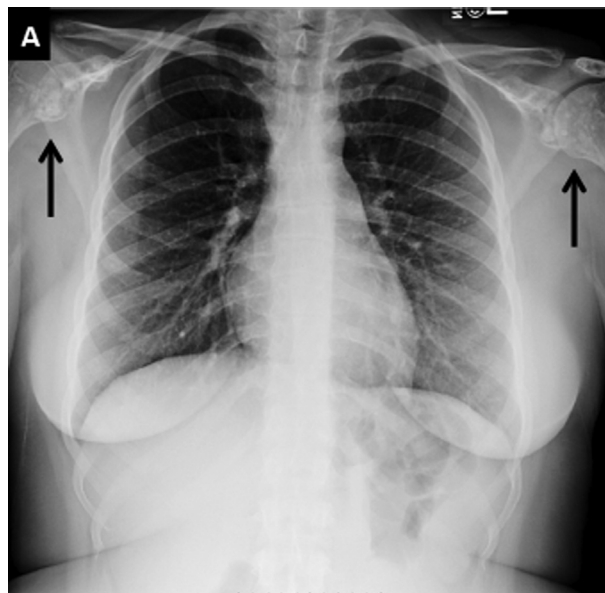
Osteopoikilosis: frontal chest radiograph (A). Note the innumerable punctate sclerotic lesions in the proximal humeri and scapulae (arrows). This is often mistaken for osteoblastic metastatic disease (typically prostate in men and breast in women). These lesions do not demonstrate any increased uptake on a bone scan whereas osteoblastic metastatic disease should show marked uptake.
